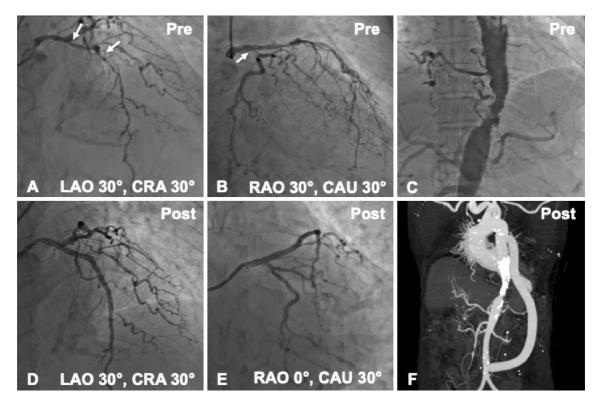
(A) A preoperative coronary angiogram (CAG) of the LAO 30° and CRA 30° view showing diffuse 90% narrowing of the LAD (arrow). (B) A preoperative CAG of the RAO 30° and CAU 30° view showing 90% narrowing of just proximal of the LCx (arrow). (C) A preoperative aortagram showing marked stenosis in the descending aorta. (D, E) A post-culotte stenting technique CAG revealing good dilation of both the LAD and LCx. (F) Postoperative CT of descending aorta-abdominal aorta bypass surgery. CAU: caudal, CRA: cranial, CT: computed tomography, LAD: left ascending descending artery, LAO: left anterior oblique, LCx: left circumflex artery, RAO: right anterior oblique
